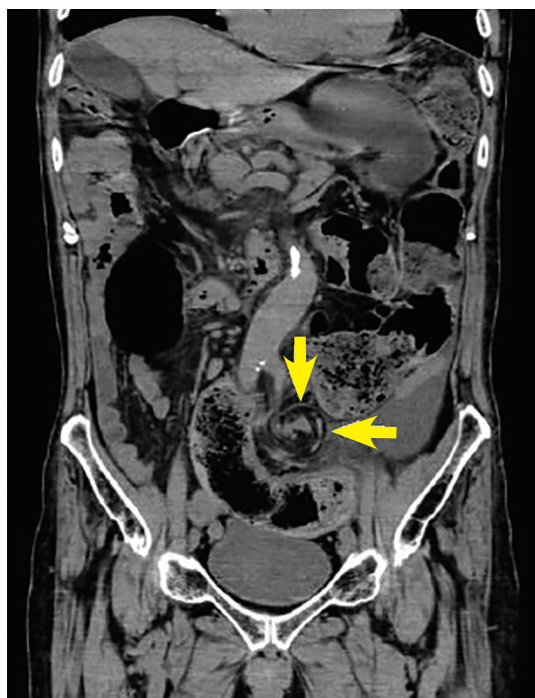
Computed tomography coronal view showed the whirl sign, representing twisted bowel and mesentery (arrows).
